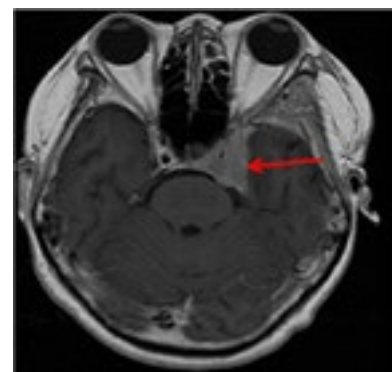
Axial T1 weighted magnetic resonance image with gadolinium enhancement demonstrating an inhomogeneous mass in the left side of the cavernous sinus (red arrow).
